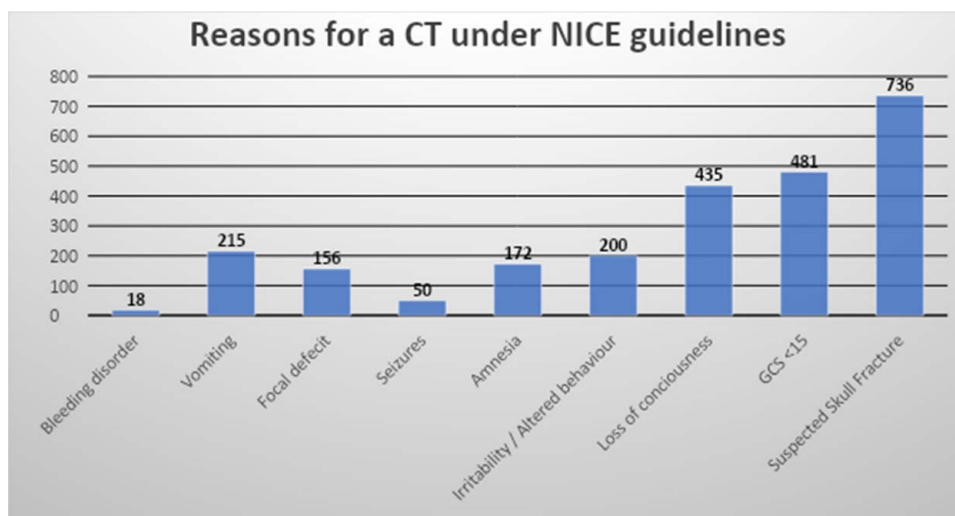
Reasons for computed tomography under the National Institute for Health and Care Excellence guidelines.
